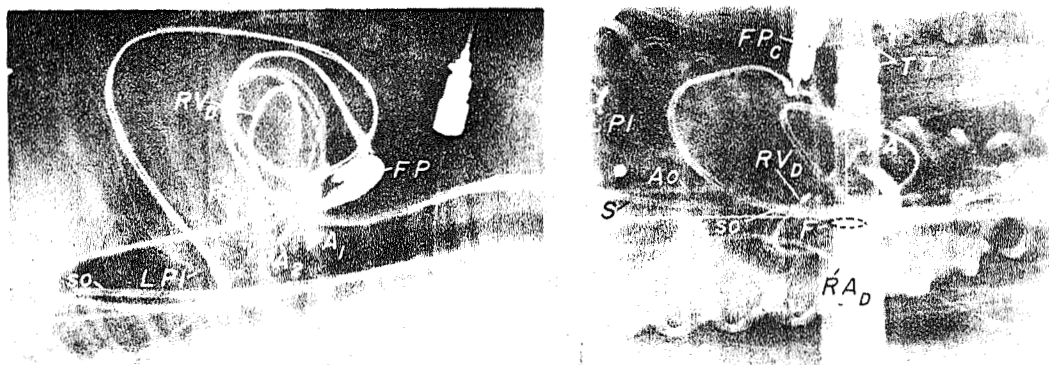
Lateral roentgenogram before beginning of liquid breathing (left) and dorsal-ventral roentgenogram during liquid breathing (right).
